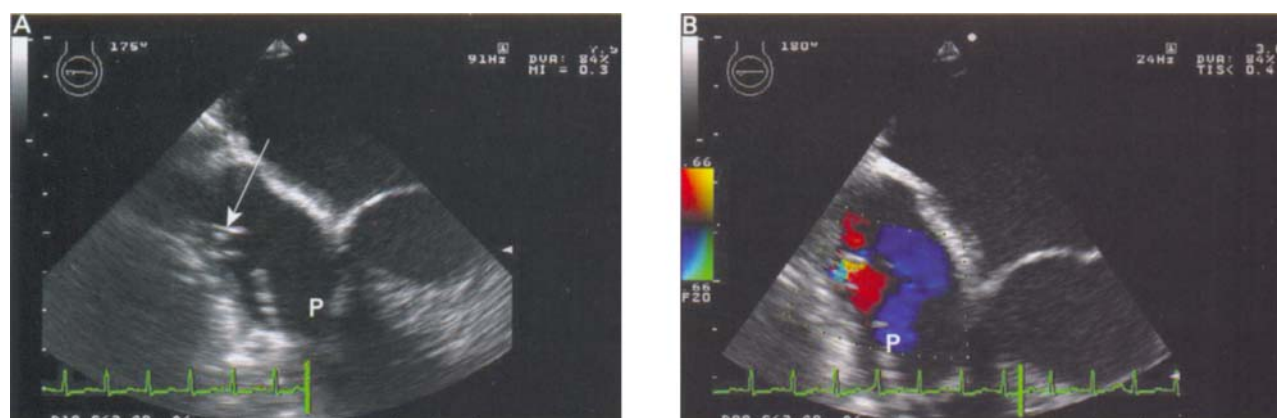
Right ventricular assist device (RVAD) inflow cannula placed laterally in the right atrium, visualised in the (A) mid-oesophageal four chamber view (arrow). (B) Colour flow Doppler shows laminar flow toward the cannula and flow acceleration at the cannula entrance. A pacing wire is visible in the right atrium (P).
